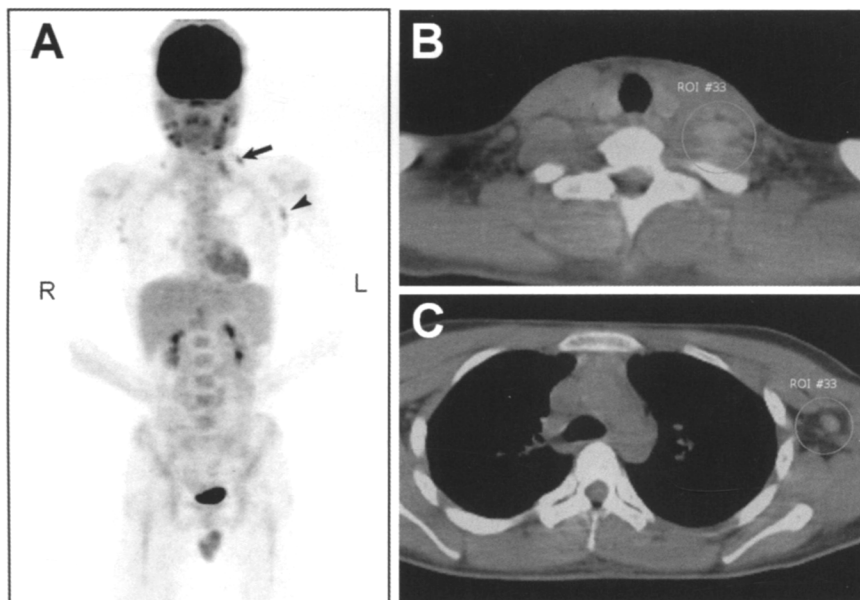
Multiple focal areas of increased FDG uptake were seen in the bilateral neck (level II–IV), left supraclavicular (arrow), and axillary (arrowhead) regions in the PET scan (*A*). PET-CT fusion imaging shows high FDG uptake in the left supraclavicular region (circle ROI on *B*, SUV 3.3) and in the left axillary region (circle ROI on *C*, SUV 2.8). ROI: region of interest; SUV: standardized uptake value.
